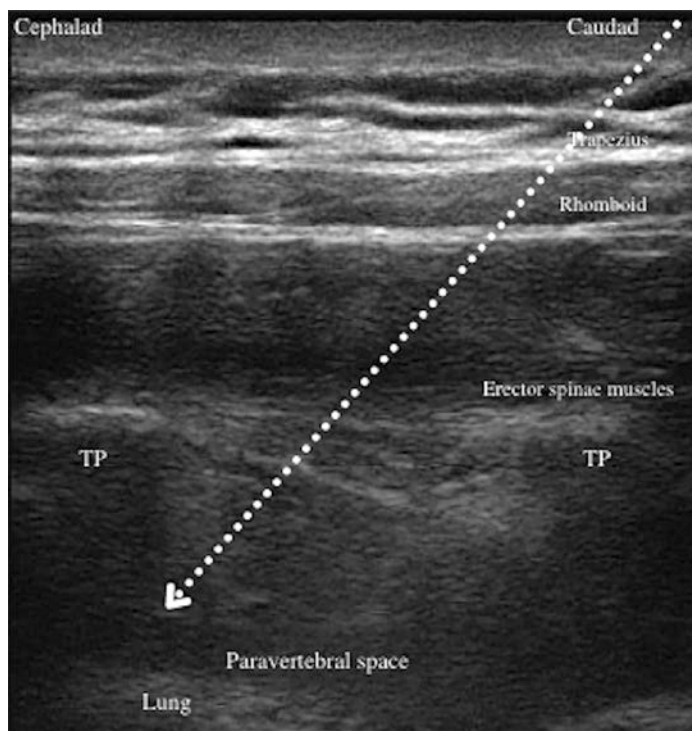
Ultrasound image of paravertebral block in sagittal plane. Dotted line represents needle trajectory with arrow pointing to site of local deposition
